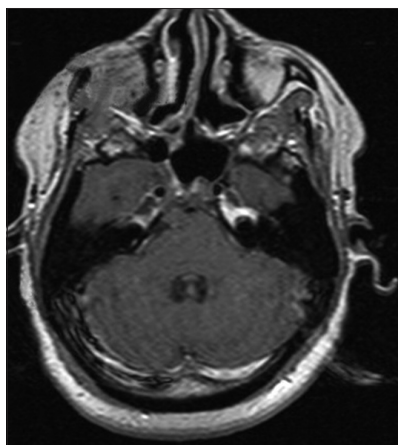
Axial postoperative MRI T1 imaging showing no signs of recurrent tumor
